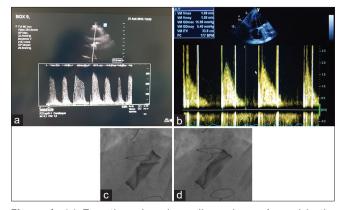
(a) Transthoracic echocardiography performed in the emergency room showing a mean transprosthetic mitral gradient of 20 mmHg; (b) Transthoracic echocardiography showing normalization of transprosthetic mean gradient (5 mmHg) 4 h after starting thrombolytic therapy. Cinefluoroscopy showing almost complete blocking leaflets in closed position. (c) diastolic image, (d) systolic image
